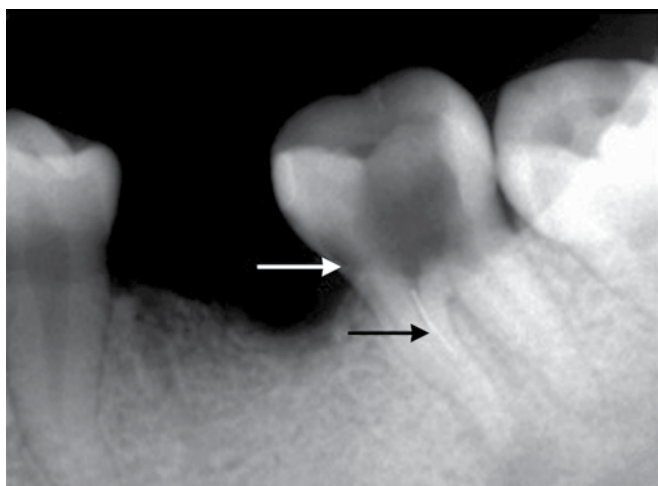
Preoperative radiograph showing separated instrument in the mesiobuccal canal (black arrow); perforation (white arrow) in the cervical area of the mesial surface of 37
